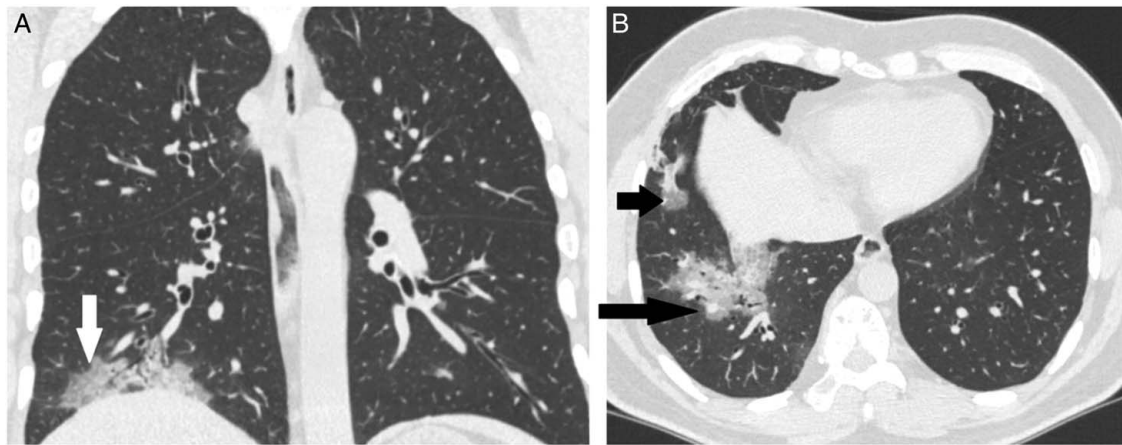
High-resolution computed tomography images in the coronal plane (A) and the axial plane (B) show consolidative changes and ground glass opacities in the right lung, predominantly toward the periphery [white arrow in (A) and black arrows in (B)].
